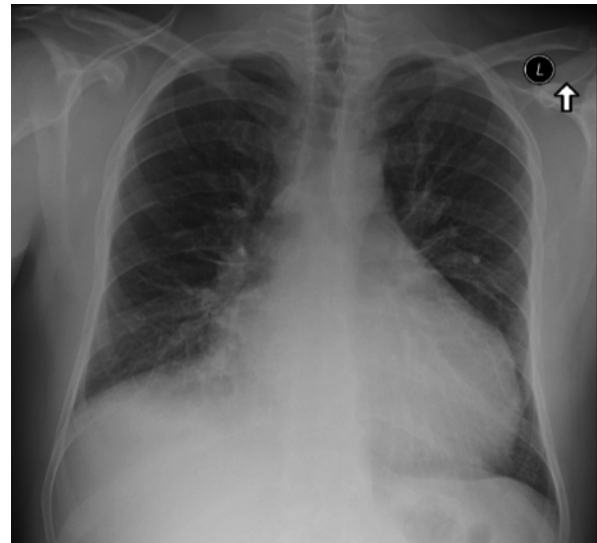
Chest X-Ray of a presented patient
